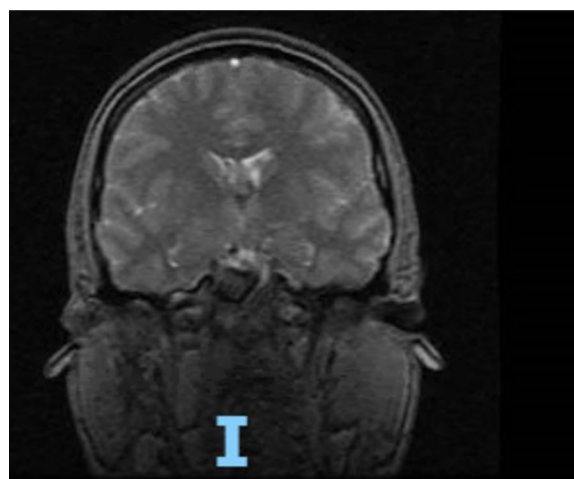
MRI head showing nodular leptomeningeal enhancement
